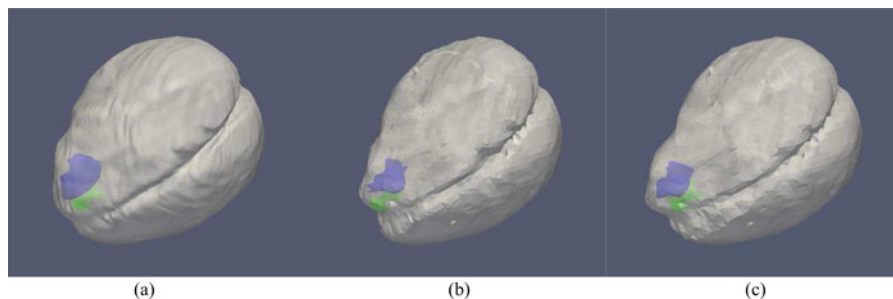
Rendering of the conoprobe points (green), tumor (blue), and brain surface (gray) for patient 5 before (a) and after (b) correction. The conoprobe points lie well below the tumor, likely due to cavity collapse during surgery. For comparison, correction using homologous points from postoperative MRI scans described in Section III-B2. (a) Patient 5: No correction. (b) Patient 5: With correction. (c) Patient 5: With correction.
